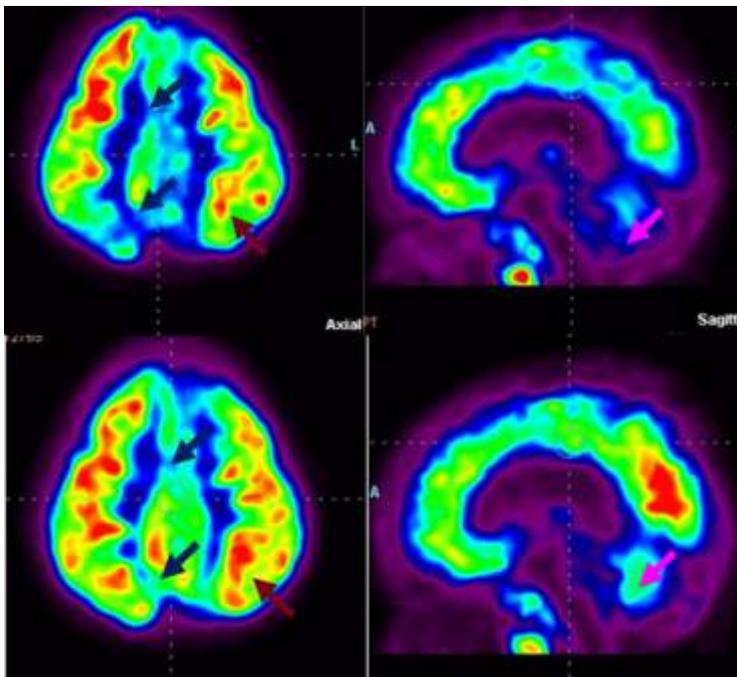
PET-CT scan images pre-stem cell therapy and post stem cell therapy. (Colour code: black- severe hypometabolism, blue-hypometabolism, green-normal metabolism): The areas marked with the arrows depict the areas of the brain which have improved post intervention. Improvement recorded in metabolic activity of cerebellum, cingulate regions, vermis and parietal gyrus.
